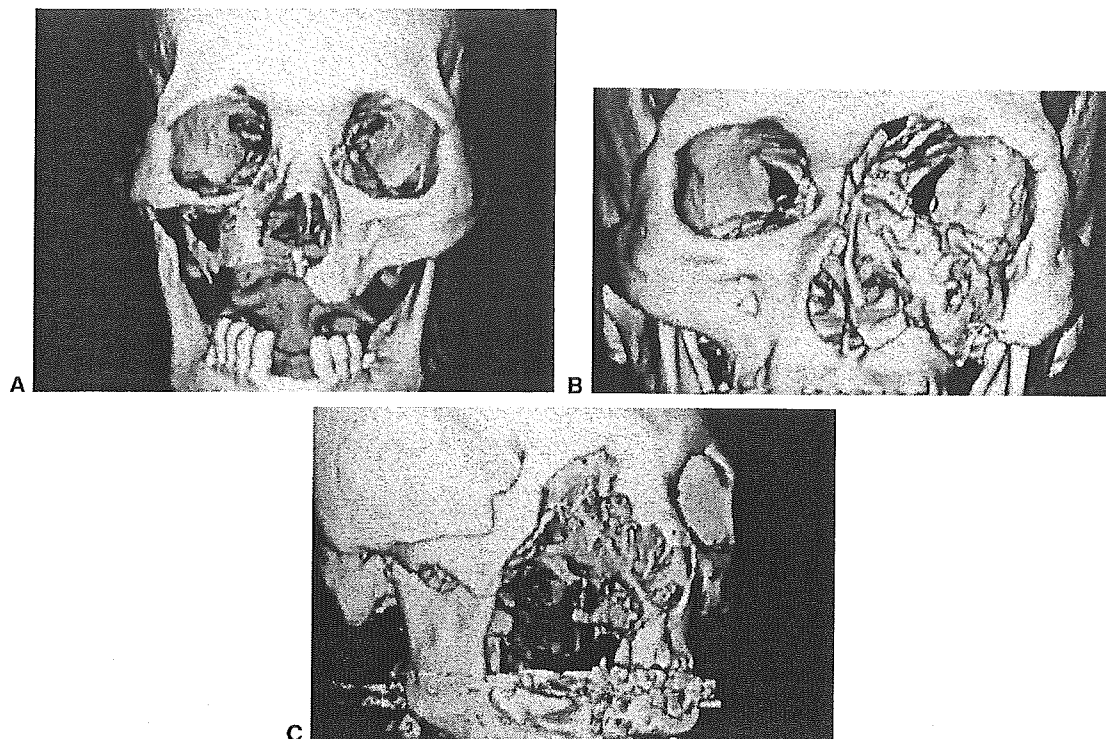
(A) Category I of maxillectomy defect in three-dimensional CT scan. PMB and NMB are removed. Limited maxillectomy and subtotal maxillectomy are included in this category. (B) Category II of maxillectomy defect in three-dimensional CT scan. ZMB and NMB are removed. Orbitomaxillectomy and orbitozygomaticomaxillectomy are included in this category. (C) Category III of maxillectomy defect in three-dimensional CT scan. All three buttresses are removed. Total maxillectomy and extended total maxillectomy are included in this category.
